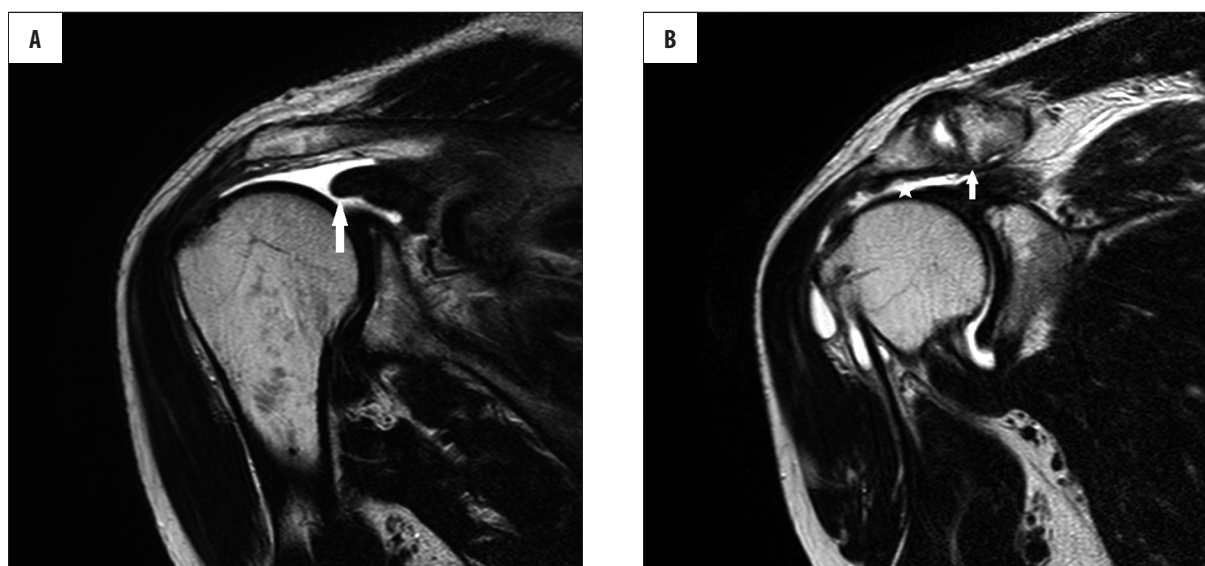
Shoulder MRI. (A) T2-weighted image, frontal plane. Complete tear of supraspinatus tendon with retraction of the torn edge and muscle atrophy (arrow). (B) T2-weighted image, frontal plane. Narrowing of subacromial space (star). Acromioclavicular joint arthrosis (arrow). Increased volume of intraarticular fluid. Subacromial-subdeltoid bursa fluid.
